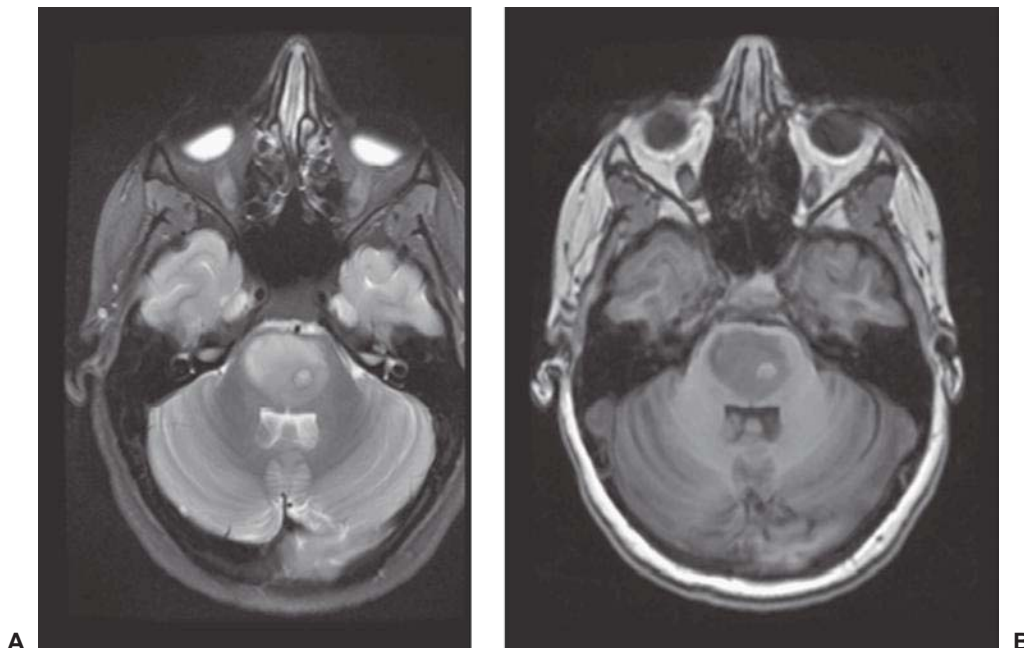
Typical magnetic resonance appearance of a diffuse pontine glioma. Diffuse enlargement of the pons is visualized on the T2-weighted image (A); a small amount of hemorrhage is visualized on the noncontrast T1-weighted image (B).
